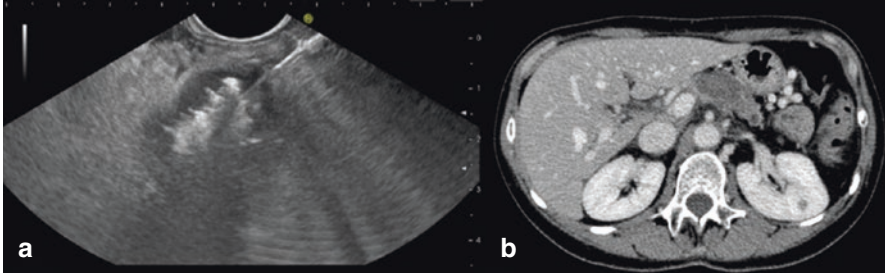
(a) Gas bubbles formation during an endoscopic ablation of LAPC within the center of the tumor. (Courtesy of Dr. Stefano Francesco Crinò, MD.) (b) One-month triple-phase contrast-enhanced CT-scan showing post-ablation necrotic area. (Courtesy of Prof. Mirko D’Onofrio)
